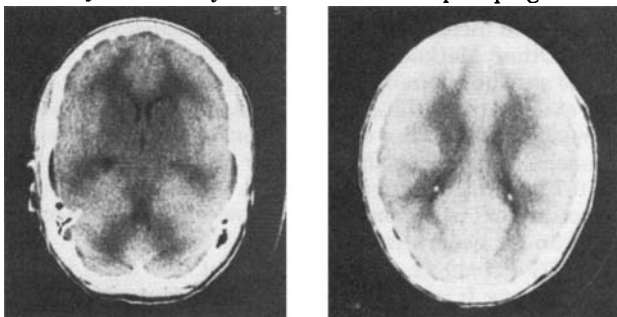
Nonenhanced CT 20 hours after metrizamide myelography. Diffuse gray matter enhancement is present (Hounsfield unit 62 within the small square on the right), which leads to the illusion of diffuse white matter hypodensity (white matter is of normal density—Hounsfield unit 31).
